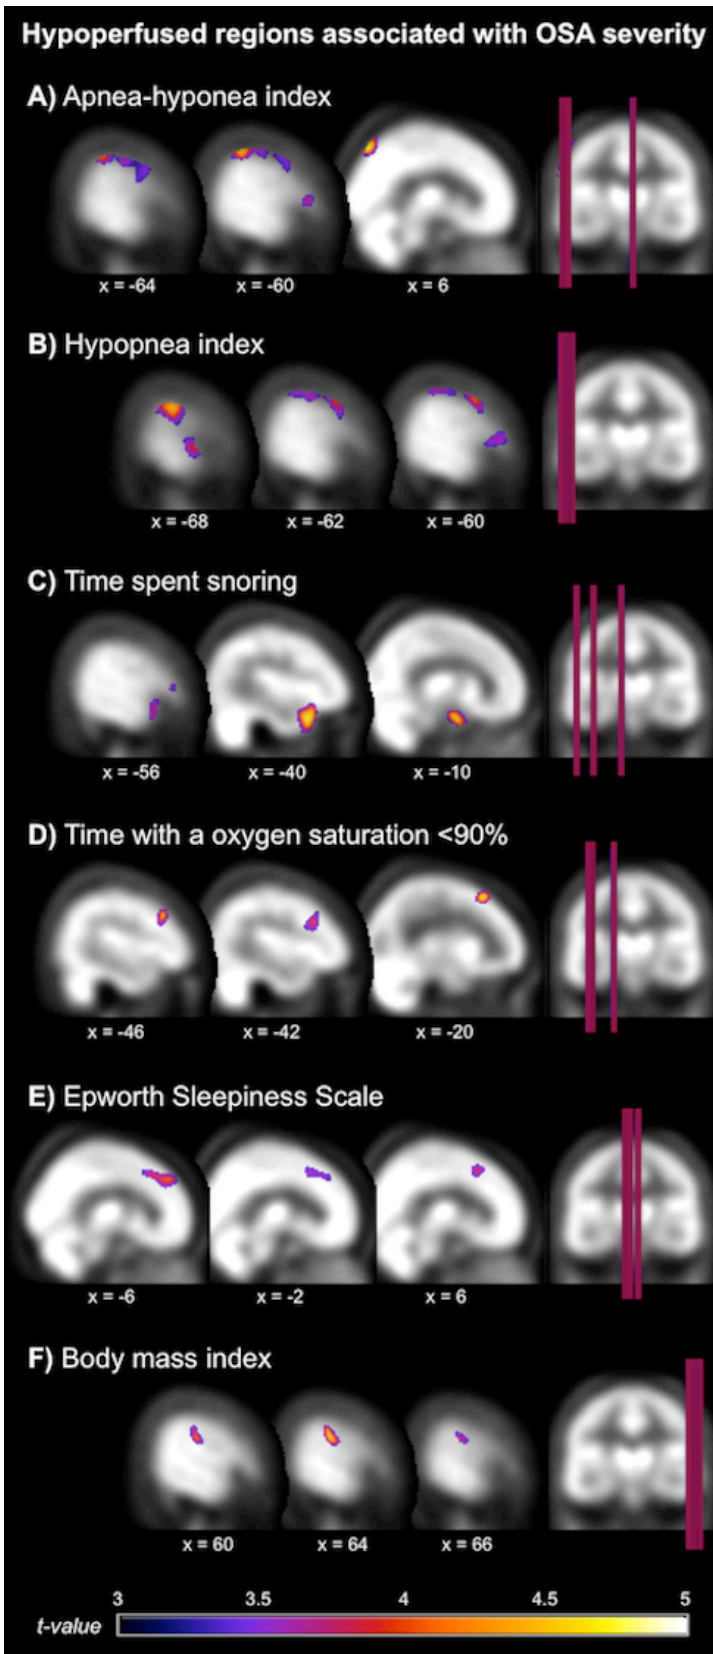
Location of hypoperfusions that correlated with variables representing more severe obstructive sleep apnea (OSA). Regions showing hypoperfusions were as follow: A) and B) left inferior and middle frontal, precentral, postcentral, and middle temporal gyri, inferior parietal lobule, and right precuneus; C) left parahippocampal, anterior temporal pole, and inferior frontal gyri; D) left dorsolateral prefrontal cortex; E) bilateral dorsomedial prefrontal cortex; F) right postcentral gyrus. Results are overlays on the SPECT template and left side of images represent the left hemisphere of the brain.
